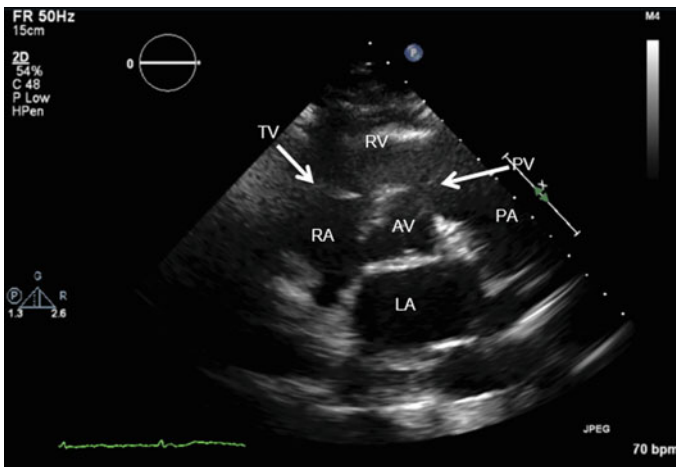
Parasternal SAX view of the AV. LA left atrium; RA right atrium; TV tricuspid valve; RV right ventricle; PV pulmonic valve; PA pulmonary artery; AV aortic valve
